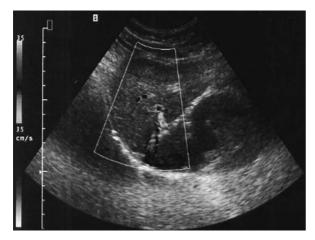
The Doppler ultrasonography revealed the patent vena portalis
